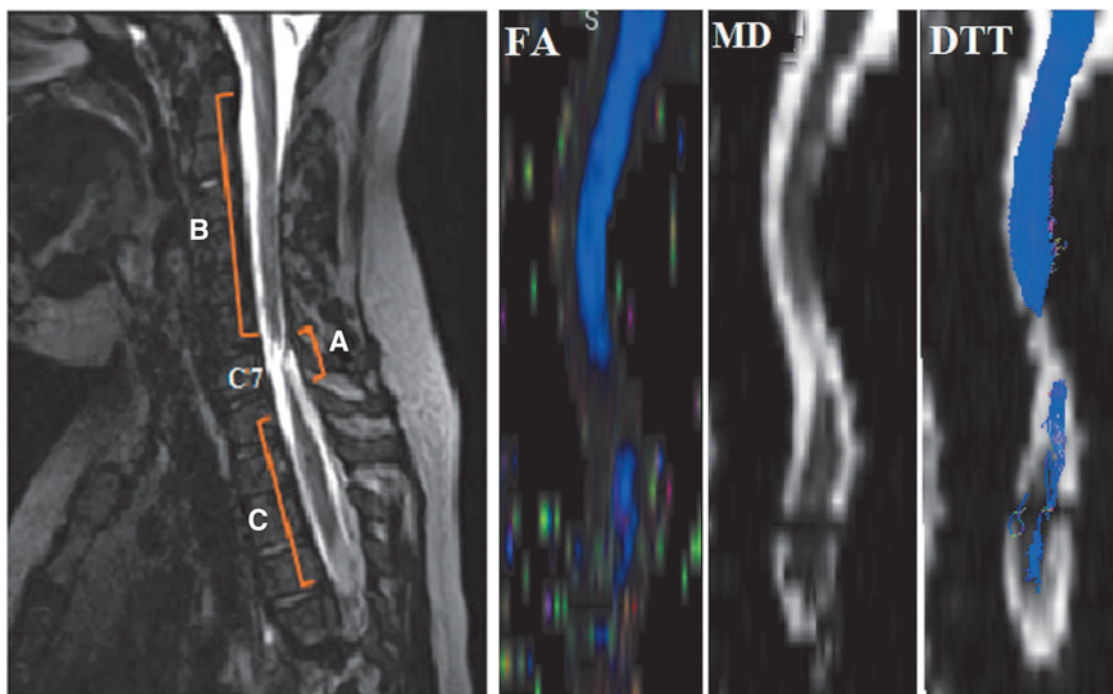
Sagittal T2-weighted image of a representative subject with chronic traumatic injury in the cervical area (left) and FA, MD and tractography images created by DTI data (right). Three regions relative to injury: regions superior to injury epicenter (B), at injury epicenter (A), and inferior to injury epicenter (C) were identified. Injury epicenter for this subject located at C7 vertebral level. DTT, diffusion tensor tractography; FA, fractional anisotropy; MD, mean diffusivity. Color image is available online at www.liebertpub.com/neu
